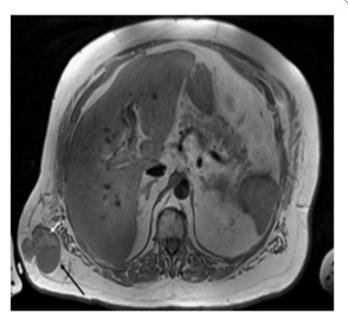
T1-weighted MRI reveals mushroom shaped posterior wall mass (black arrow) with hyperintense internal composition (white arrow) representing fat.
